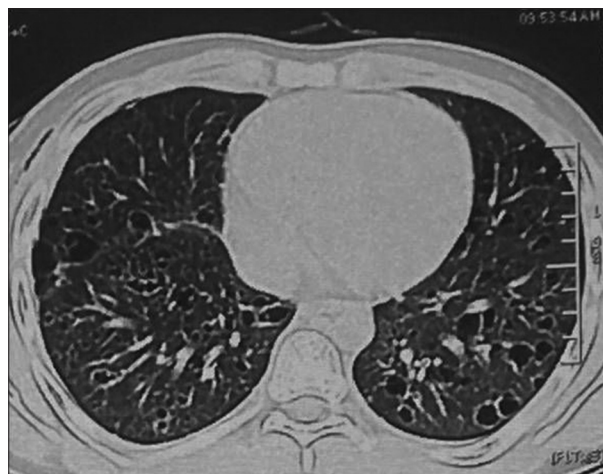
Computed tomography thorax (lung window section) showing multiple variable sized thin-walled cysts in both the lungs
